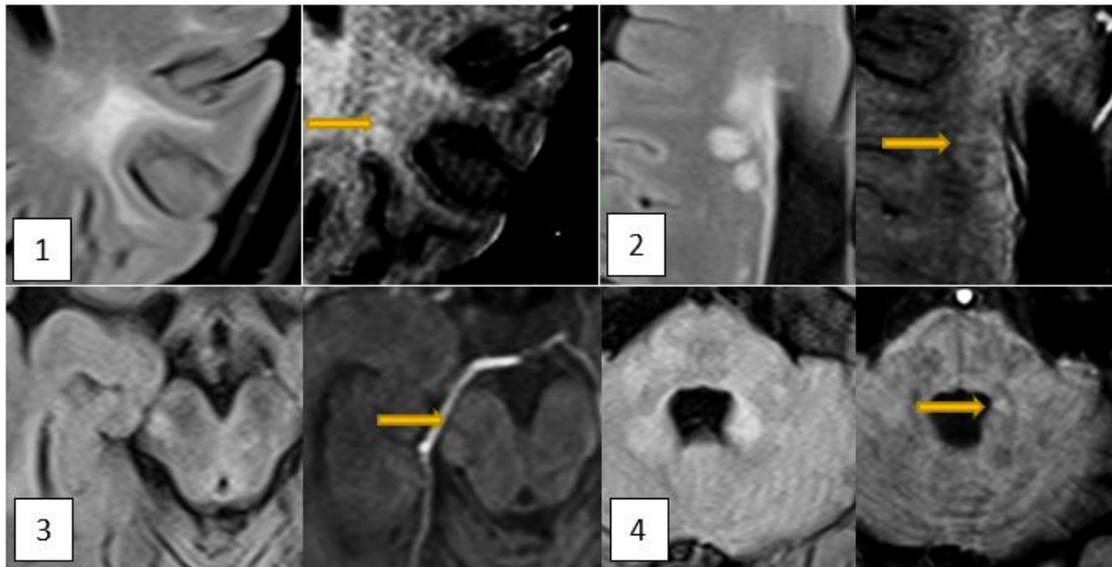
Central Vein Sign. Axial FLAIR and SWI images showing the Central Vein Sign in juxtacortical (1), periventricular (2) and infratentorial (3,4) locations.
